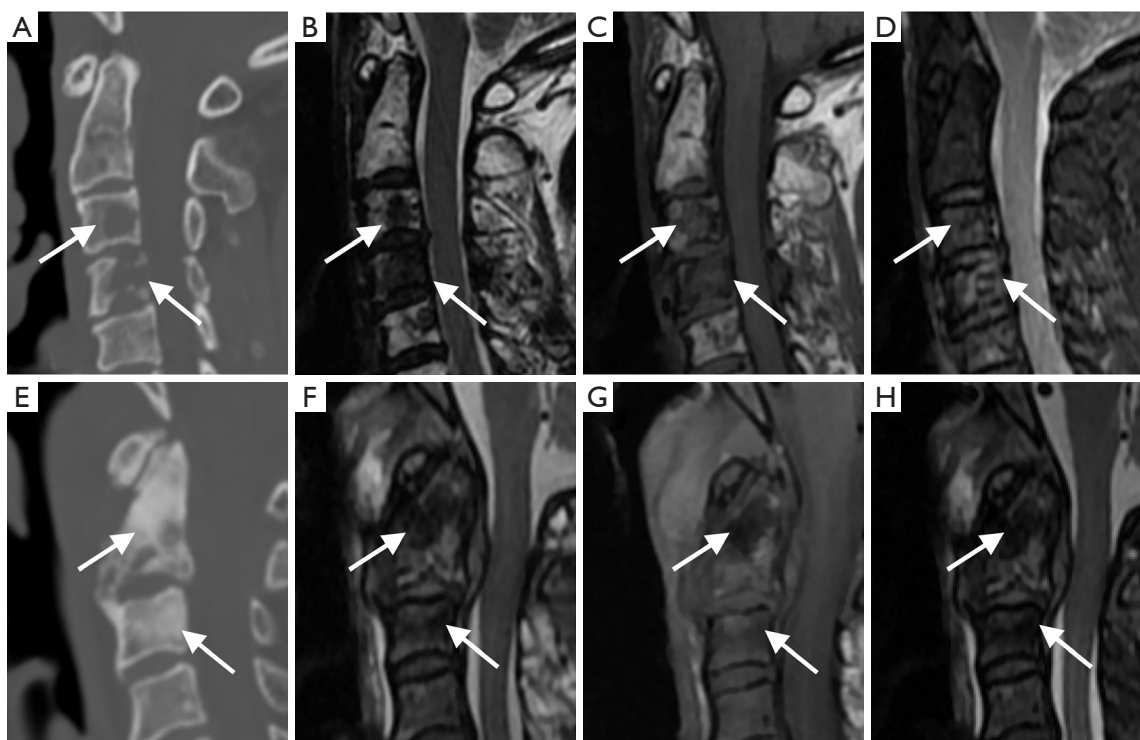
Two examples correctly predicted as predominantly osteolytic and osteoblastic spinal metastases by only the radiomics model. (A,E) CT images; (B,F) T2WS images; (C,G) T1WS images; and (D,H) FS-T2WS images. Predominantly osteolytic spinal metastases in a 54-year-old woman with thyroid carcinoma (arrows in A-D). The lesion indicated by the arrows is low signal intensity on T2WS, iso-signal intensity on T1WS, and uneven high signal intensity on FS-T2WS, with soft tissue mass and no severe compression fractures. Predominantly osteoblastic spinal metastases in a 62-year-old man with hepatocellular carcinoma (arrows in E,F). The lesion indicated by the arrows is low signal intensity on all 3 sequences, with soft tissue masses and no severe compression fractures. CT, computed tomography; T2WS, T2-weighted sequence; T1WS, T1-weighted sequence; FS-T2WS, fat-suppressed T2-weighted sequence.
